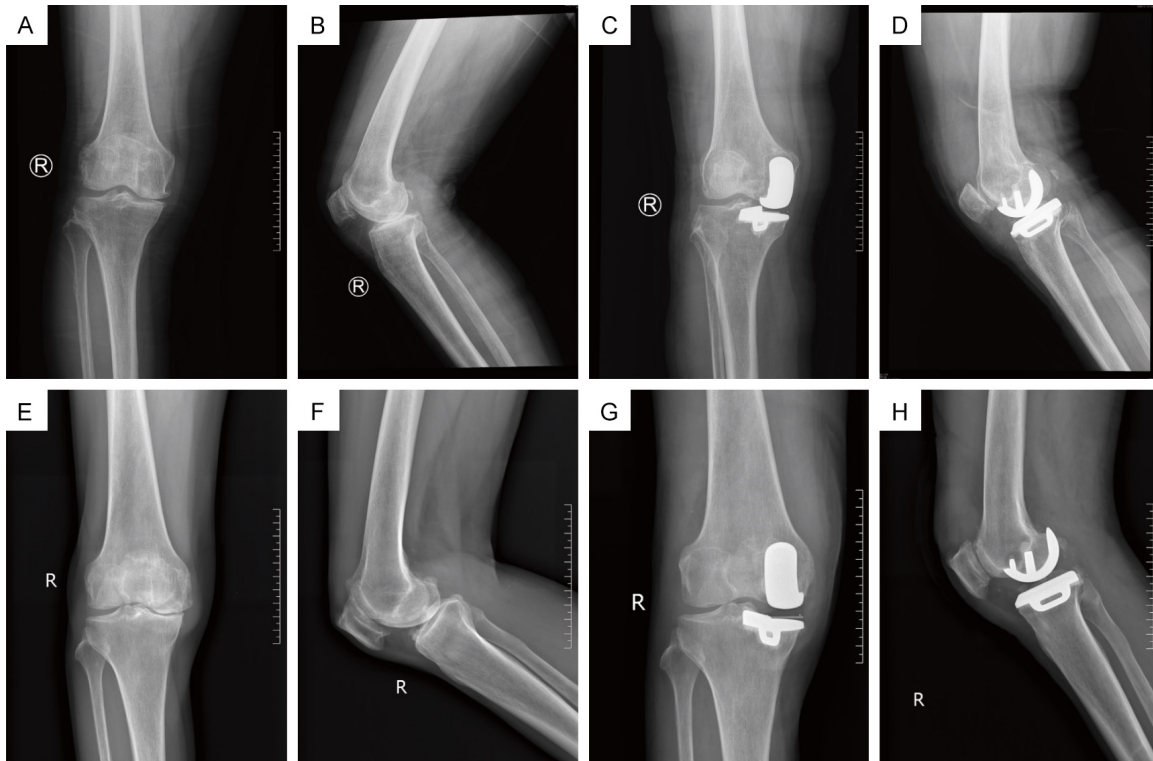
Comparison of pre-treatment and post-treatment (6 months) knee imaging. A: Preoperative anteroposterior radiograph of Case 1; B: Preoperative lateral radiograph of Case 1; C: Postoperative anteroposterior radiograph of Case 1 (6 months); D: Postoperative lateral radiograph of Case 1 (6 months); E: Preoperative anteroposterior radiograph of Case 2; F: Preoperative lateral radiograph of Case 2; G: Postoperative anteroposterior radiograph of Case 2 (6 months); H: Postoperative lateral radiograph of Case 2 (6 months).
